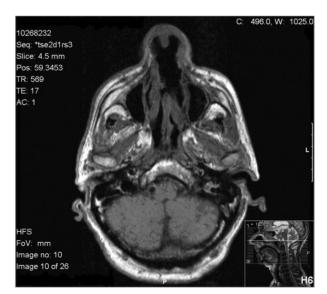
MRI showing large septal defect
